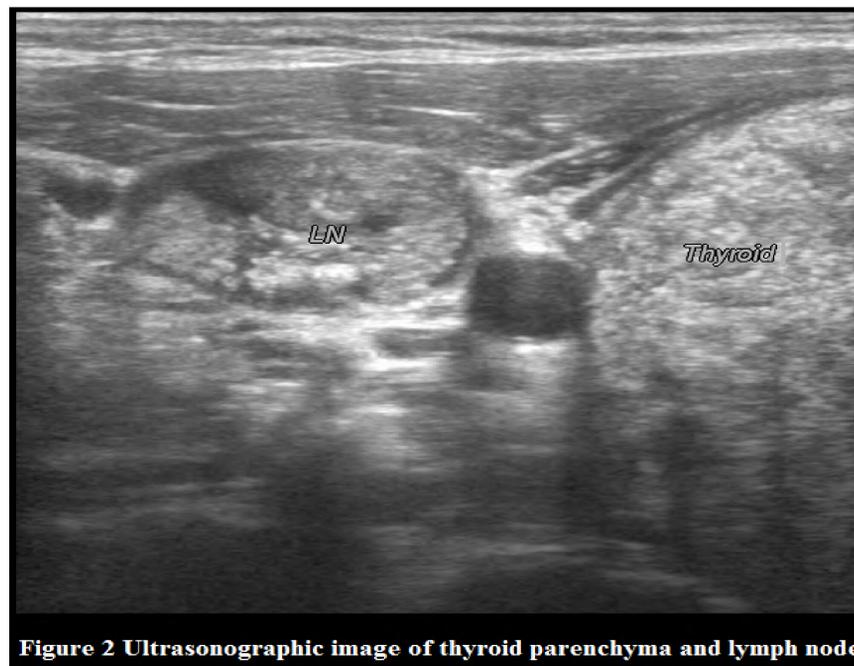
Ultrasonographic image of thyroid parenchyma and lymph node
